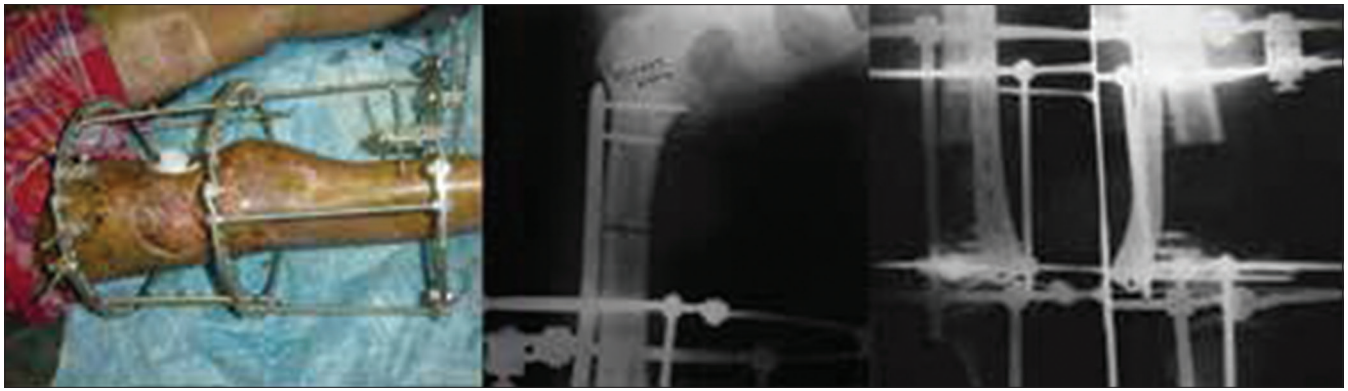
Case 1: Clinical photograph and x-rays of thigh showing Ilizarov fixator (applied at 14 weeks) and mid-femoral corticotomy (After one week of bone transport started)
